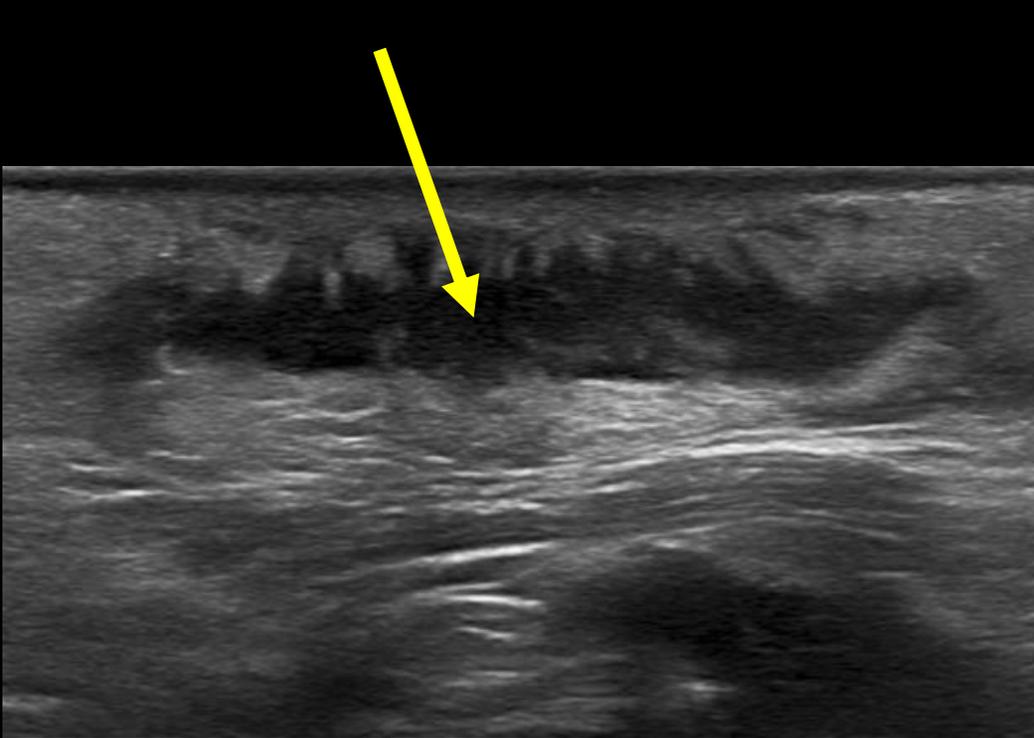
US Rt Gluteal Area. Soft tissue mass with hypoechoic component (left) containing color Doppler signal (right) and multiple arterial waveforms on pulse wave Doppler (not shown)
